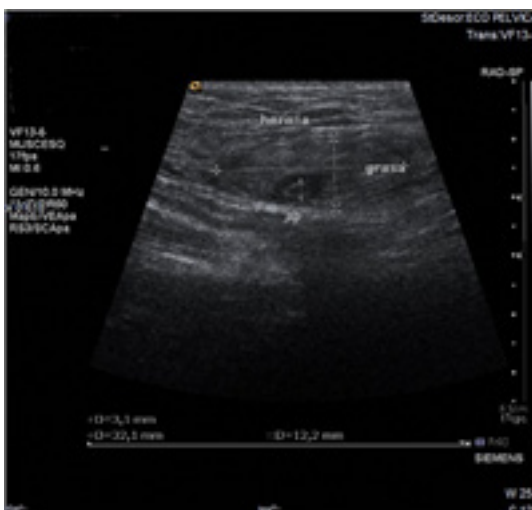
Ultrasound showing a hernial sac in the inguinal area with diameters of 32x12x11 milimeters. Abdominal fat content as well as the vermiform appendix without inflammatory changes were observed inside the hernial sac.
